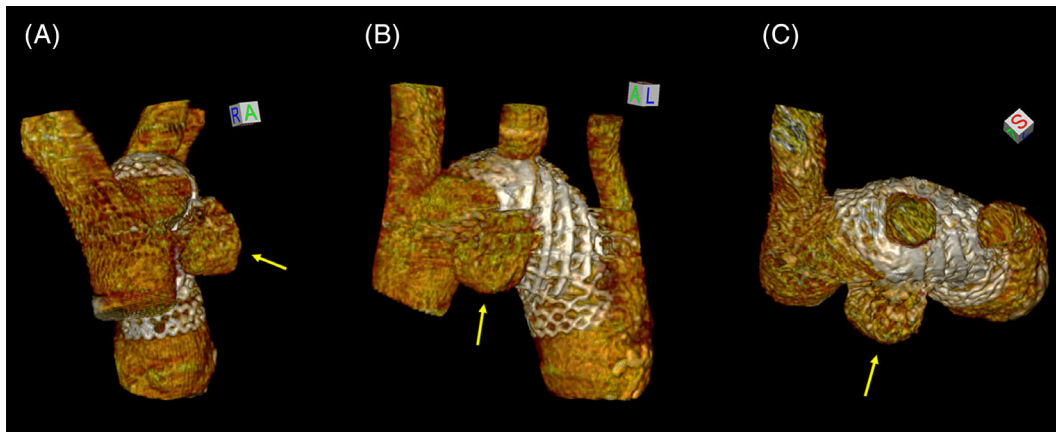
Three-dimensional reconstruction of the follow-up CTA performed after additional CP stent implantation, displayed in frontal (A), lateral (B), and cranial (C) planes. Note the 20 × 14 mm pseudoaneurysm located ventroproximally to the CP stent (yellow arrows). CP, Cheatham-Platinum; CTA, computed tomography angiography [Color figure can be viewed at wileyonlinelibrary.com]
